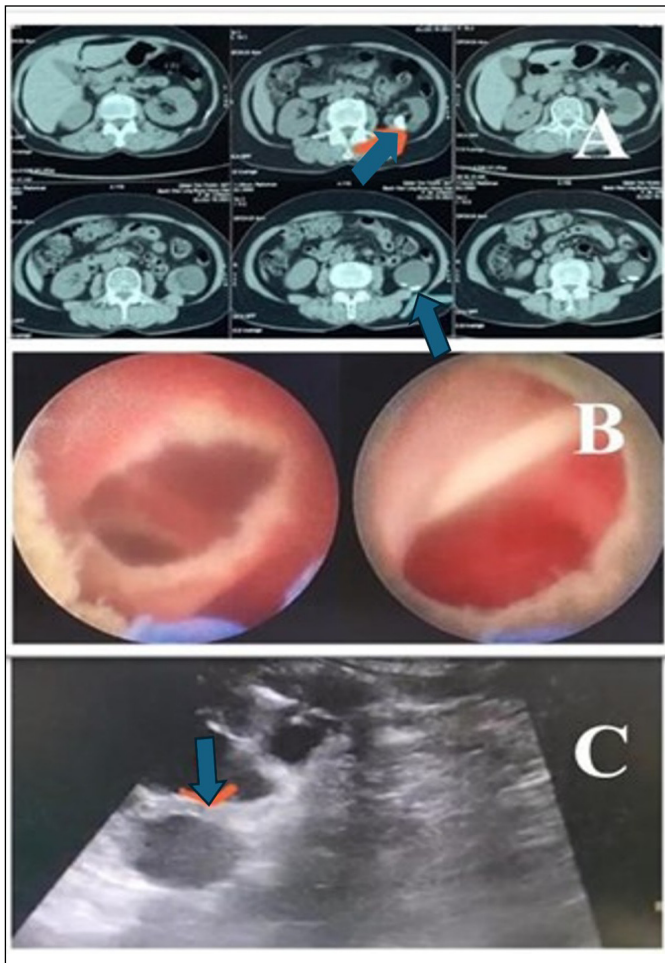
Representative images of simultaneous management: A) Preoperative CT scan demonstrating ipsilateral renal stone (red arrow) and simple renal cyst (blue arrow). B) Endoscopic view after intrarenal marsupialization, showing creation of the internal opening with placement of a double-J stent coil inside the cyst cavity. C) Ultrasonography image of a thick-walled cyst in which marsupialization was not feasible, managed with aspiration only.
